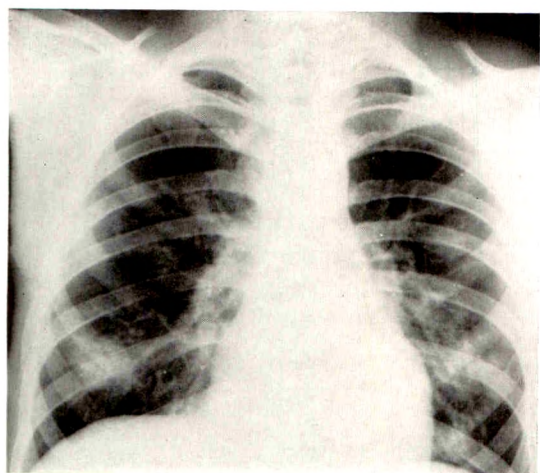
Case II. Erect posteroanterior roentgenogram of the chest shows bilateral irregular nodular infiltrations. No cavities are discernible. Hilar lymphadenopathy is present.
